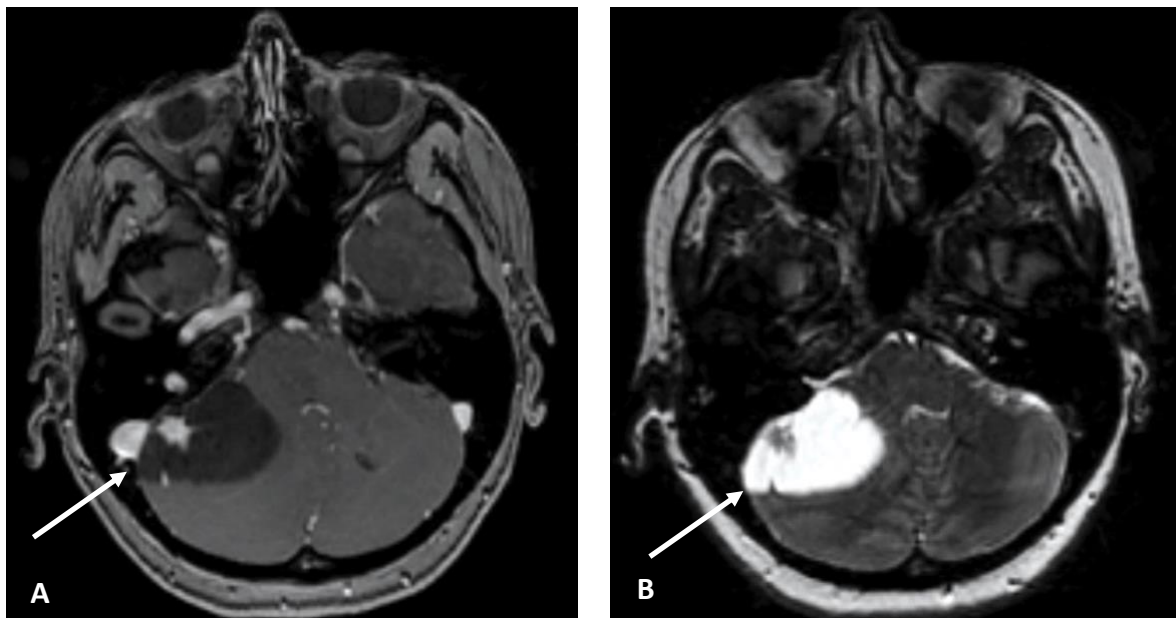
A: Contrast-enhanced T1 weighted MRI of a PA showing the characteristic solid-cystic tumour with a diffusely enhancing solid component.²³ B: T2-weighted MRI image displaying hyperintensity of the solid regions.²³
